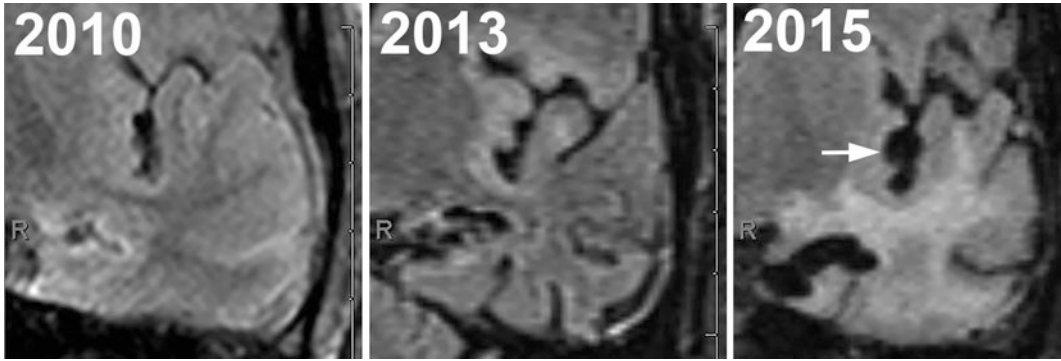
Serial coronal FLAIR images of the left temporal lobe in an adult patient with autoimmune encephalitis. Between 2010 and 2015, there was progressive volume loss and denudation of the overlying cortex (*arrow*). Similar focal lobar volume loss can happen in Rasmussen encephalitis
